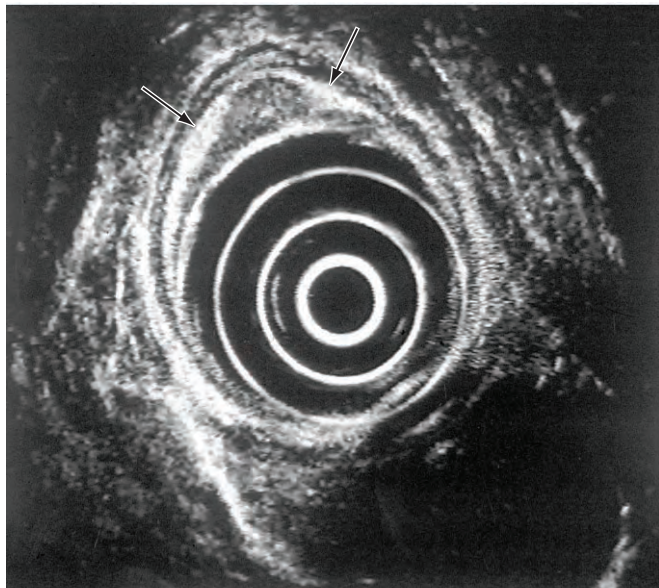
Upper*, A T1 tumor as seen on esophageal ultrasound. The hypoechoic (black) tumor invades the hyperechoic (white) third ultrasound layer (submucosa) but does not breach the boundary between the third and fourth layers (*arrows*). *Lower*, A T1 tumor invades, but does not breach the submucosa.
